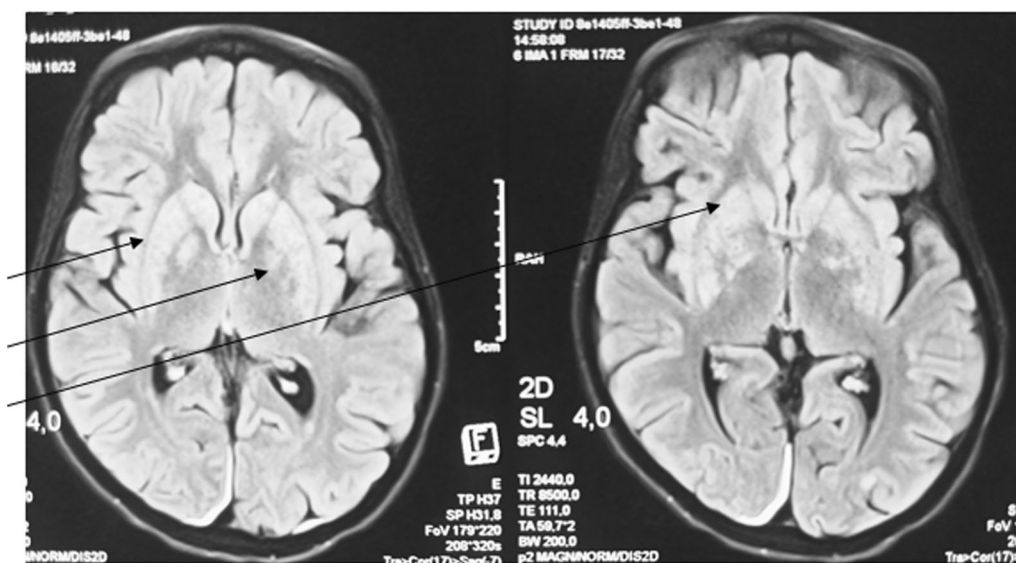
Brain MRI in FLAIR sequence showing bilateral and symmetrical hypersignals of the basal ganglia (black arrow)
